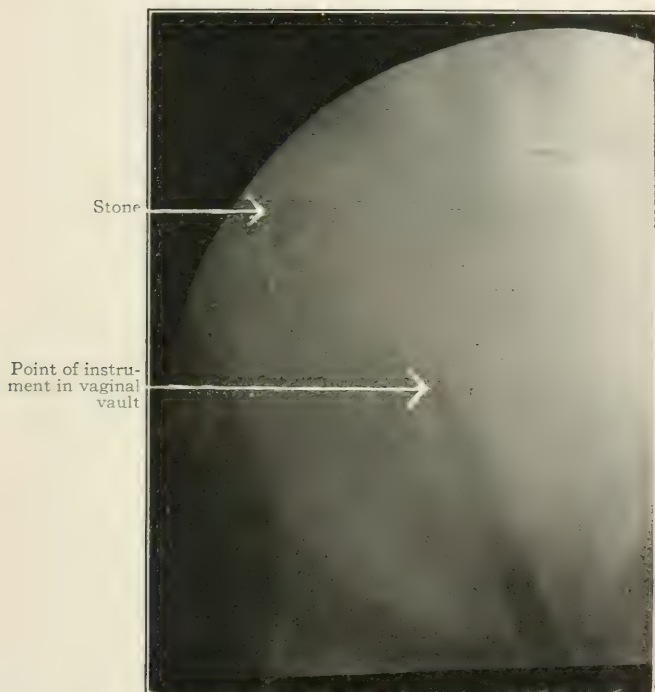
In the reduced radiograph the shadow of the thickened ureter is lost, and that of the stone very faint. The instrument indicates the direction of the vagina, and its point touches the thickened portion of the ureter.
